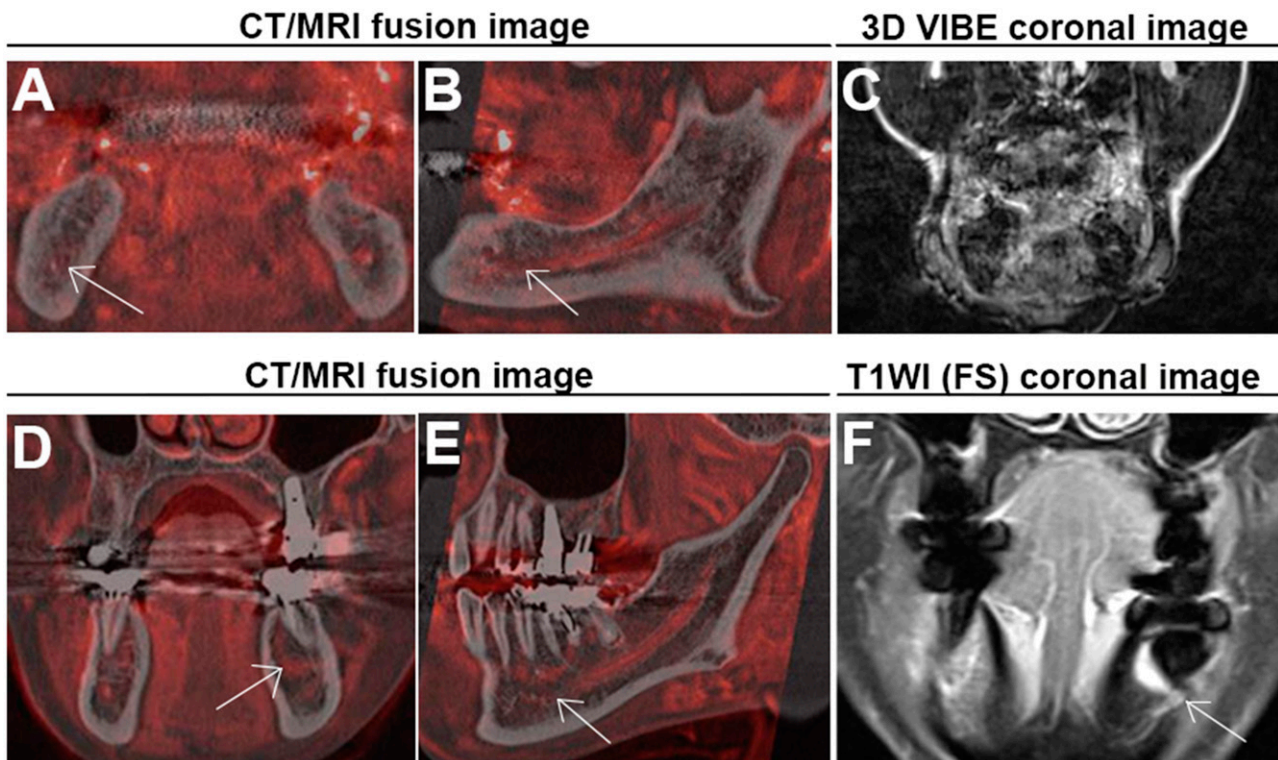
Two cases in which CT/MR volumetric fusion images that did not help with mandibular canal (MC) identification. (a) The arrow indicates the small pattern in the premolar (PM) area. (b) The neurovascular bundles (NVBs) had some fluctuations through the course of the MC (arrow). (c) Coronal three-dimensional volumetric interpolated breath-hold examination (3D-VIBE) image with motion artefact, which could make the NVB harder to identify. (d, e) shows a thin NVB signal in the PM area, but there was a high signal in a semi-circular band around tooth 36. (f) A coronal gadolinium-enhanced T_1 weighted image (T1WI) with fat suppression (FS) clearly showing a metal artefact in the corresponding area, which can degrade the NVB signal (arrow).
